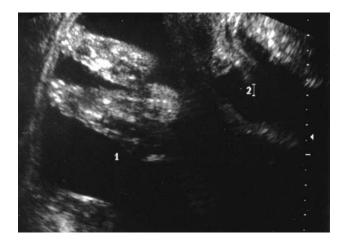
Transvaginal sonogram of a twin pregnancy at 24 weeks' gestation, full dilatation, and preceding feet of the first (1) and the second (2) twin
